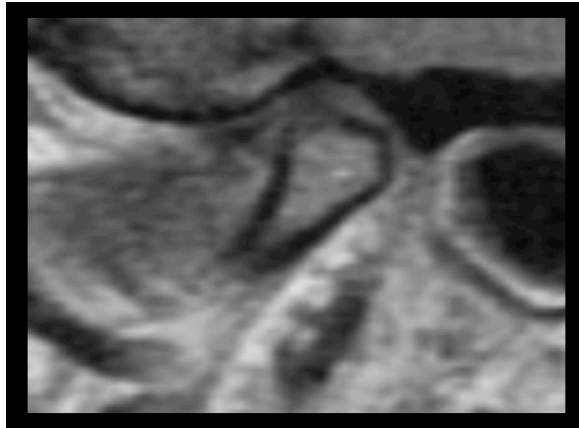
T1-weighted sagittal magnetic resonance image showing erosions on the anterior-superior aspect of the temporomandibular joint condyle head.
